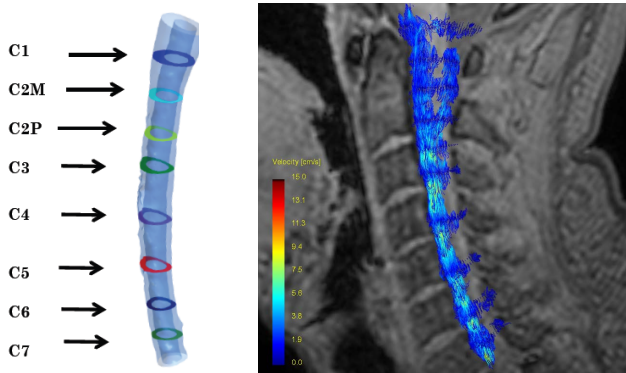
Level of 4D MRI measurements in the SSS (left) and 3D systole sagittal velocity map of CSF in the cervical subarachnoid space of Patient 1 (right).
